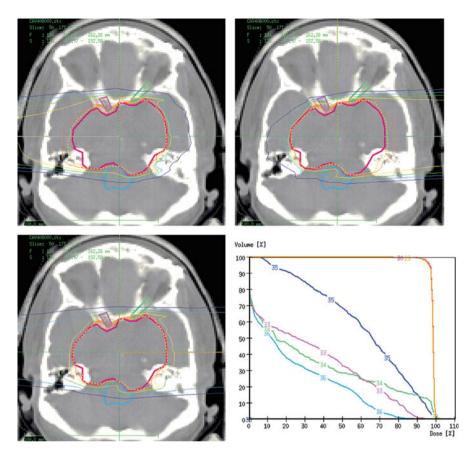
Example of a treatment plan for a skull base chordoma, using two scanned fields of carbon ions. The dose distribution for the two single beams is shown on the *top images*. The isodose lines correspond to 10% (*dark blue*), 30% (*light blue*), 50% (*green*), 70% (*yellow*) and 90% (*red*) of the dose prescribed per field, respectively. The *contours* of the planning target volume (*red line*, dose-volume histogram/DVH line 30), optical nerves (*purple* and *green contours*, DVH line 33 and 34) and brain stem (*light blue*, DVH line 36) are shown. The DVH comprises, in addition, the optical chiasm (DVH line 35) The combined dose distributions are shown in the same color code but relative to the dose prescribed per plan on the CT image (*lower left*) and in the DVH (*lower right*)
